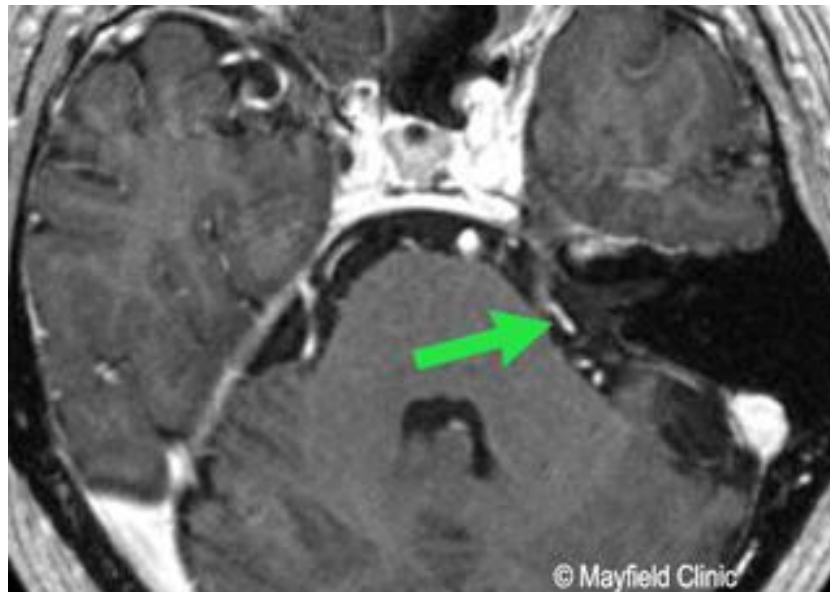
FIESTA MRI can detect blood vessels (arrow) that may be compressing the trigeminal nerve. SOURCE: *Elaini, 2013*.
